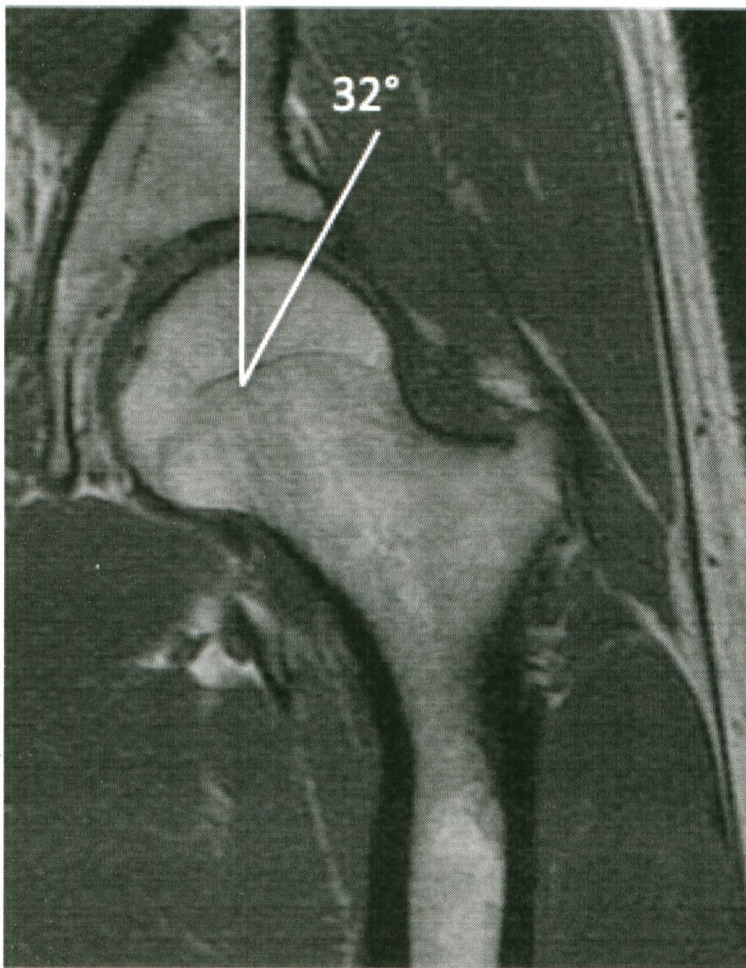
MRI of a 25-year-old male displaying a normal CE angle of 32°.
